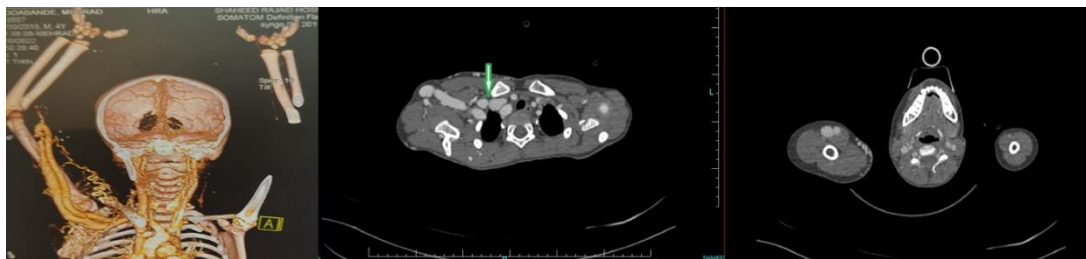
CTA of head, neck and right upper limb showing multiple serpiginous and vermiform arteries in the subcutaneous region of the right shoulder, right hemi-chest wall and right arm were noted. An abnormal AV connection between the brachial artery and vein, and also between the subclavian artery and vein, was detected. Moreover, a stenosis at the subclavian vein just before its connection to the internal jugular vein was recorded (green arrow).
